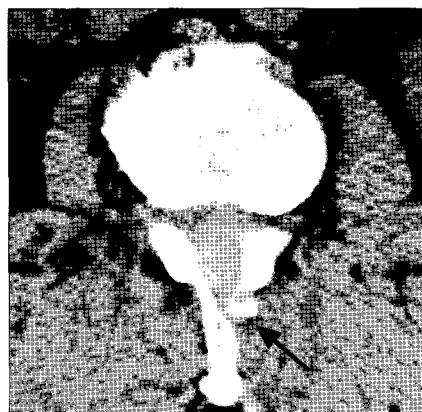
Computed tomography scan showing the acute spinal epidural hematoma at the L2-3 level. Drains were inserted on the unilateral laminectomy site (black arrow).
